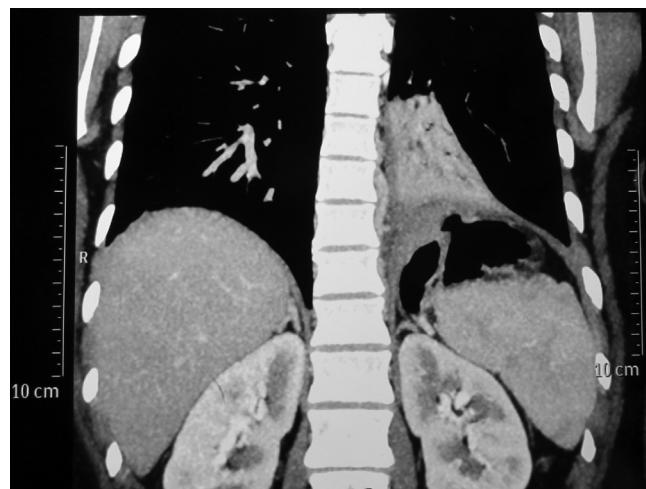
Contrast enhanced CT scan (coronal section) showing gastropulmonary fistula and consolidation of the lower lobe of the left lung.
